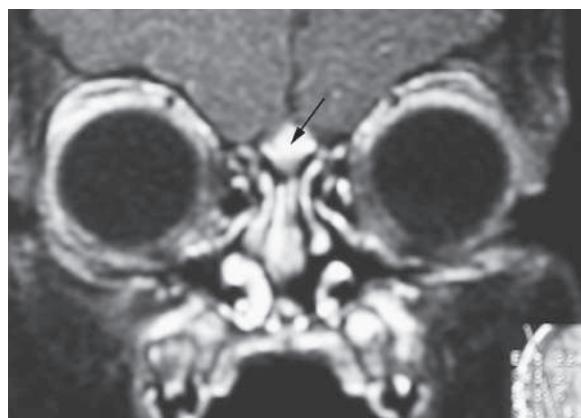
Coronal CT scan of nasal dermoid with intracranial extension (arrow). (From Manning SC, Bloom DC, Perkins JA, et al. Diagnostic and surgical challenges in the pediatric skull base. Otolaryngol Clin North Am. 2005;38:773–794, Fig. 2.)
